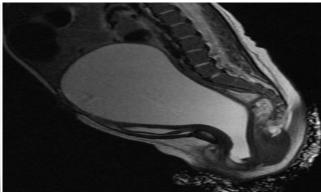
Postnatal ultrasound and MRI Results
